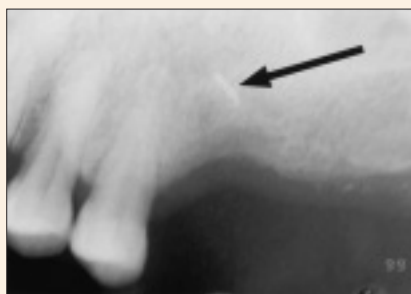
Periapical radiograph showing a linear radiopaque area (arrow) at the apical level of the previously extracted left maxillary first molar.
